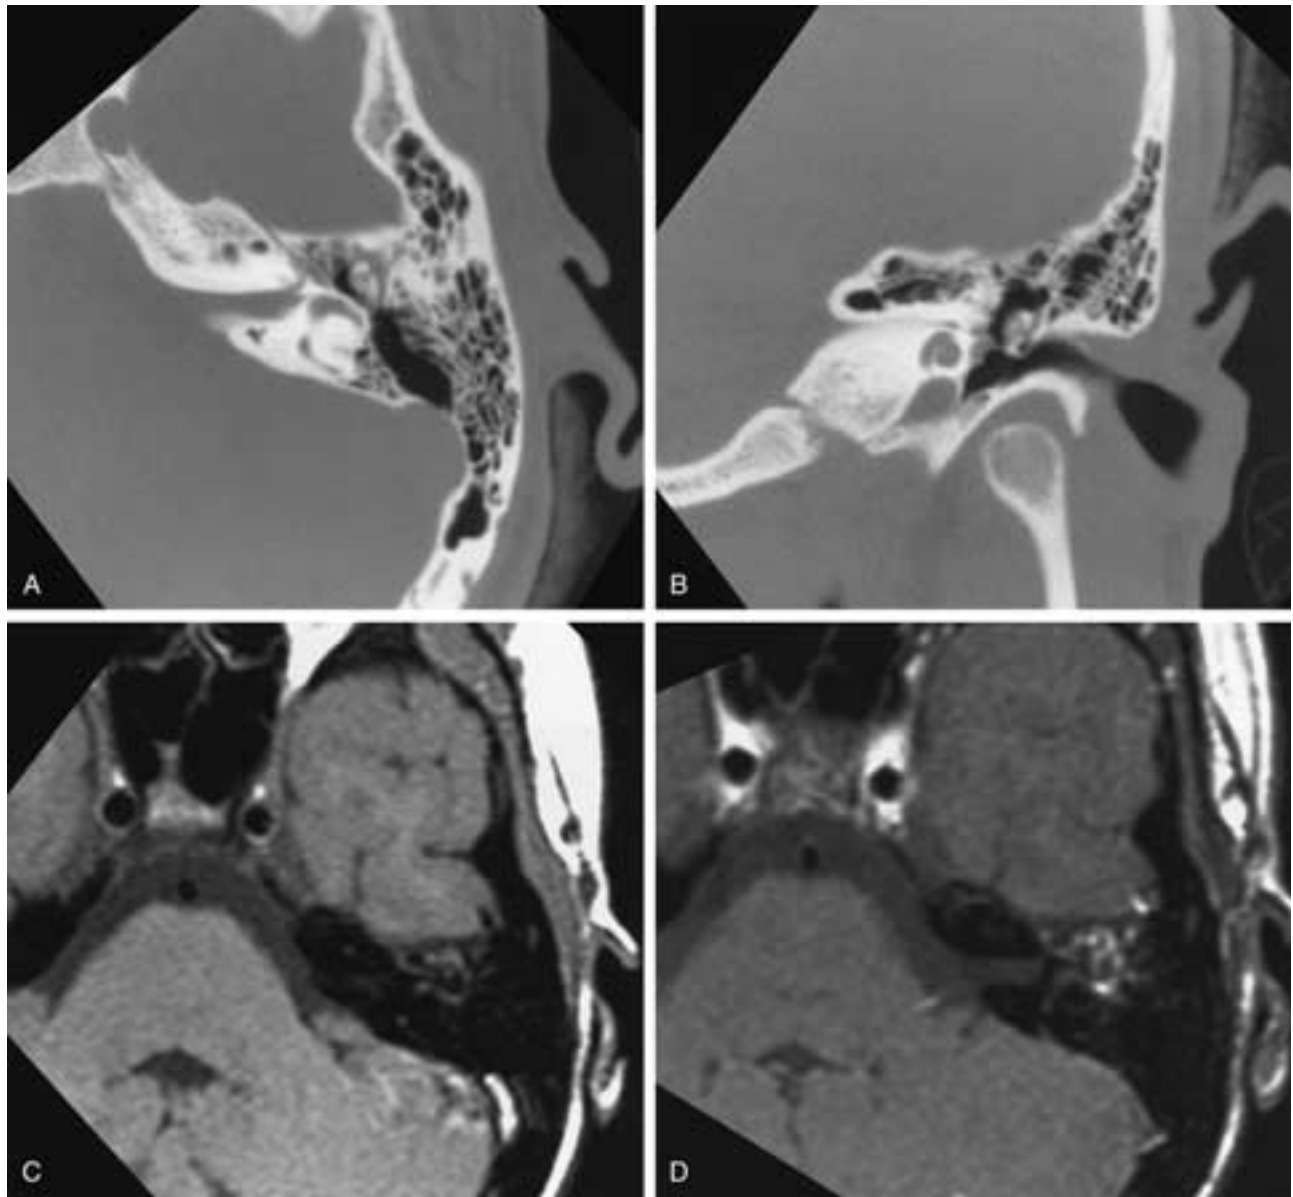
Noncholesteatomatous erosion of ossicles. A and B, Axial and coronal CT images show erosion of ossicles surrounded by soft tissue debris. C and D, Axial T1-weighted MR images before and after gadolinium enhancement demonstrate only enhancing tissue surrounding the ossicles. At surgery, only granulation tissue was found.
